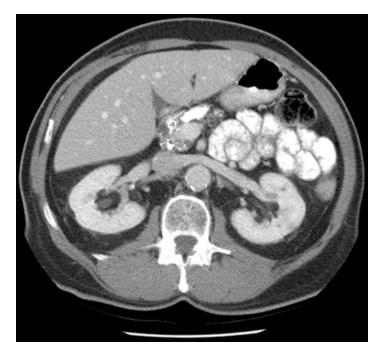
Computed Tomography scan demonstrating chronic pancreatitis with diffuse parenchymal calcifications. A large stone within the pancreatic head is seen occluding the duct of Wirsung
